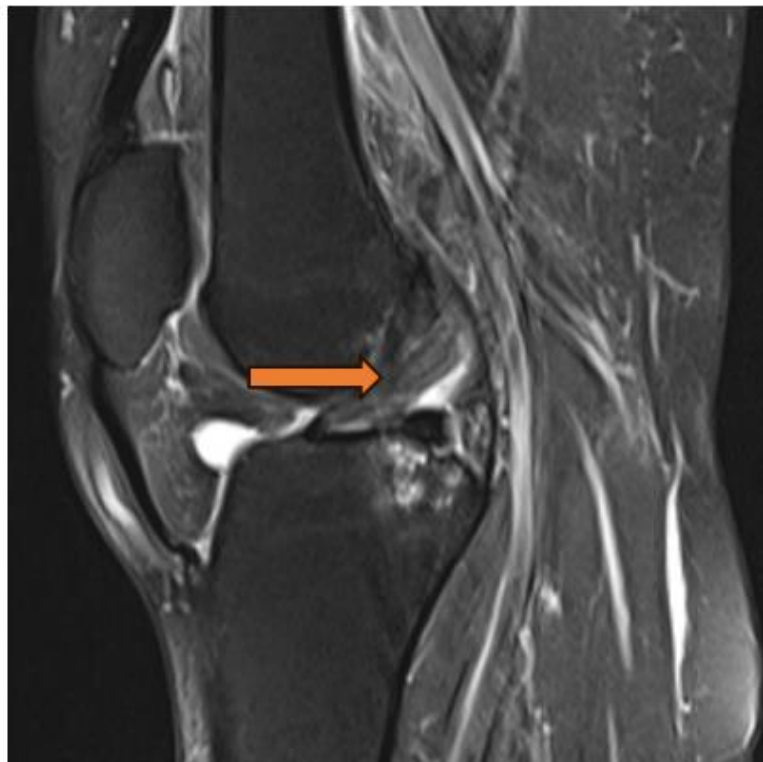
MRI Left knee joint, PDFS sagittal section showing intrasubstance hyperintensities in anterior cruciate ligament, consistent with ACL sprain
